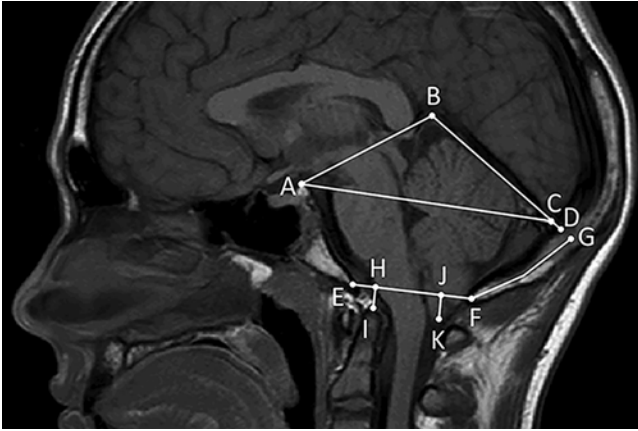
Sagittal MR image indicating morphometric landmarks and lines. Clivus-tentorium distance (AB), tentorium length (BD), clivus-torcula line (AC), McRae's line (EF), supraoccipital length (FG), basilar impression (HI), and tonsil position (JK).
